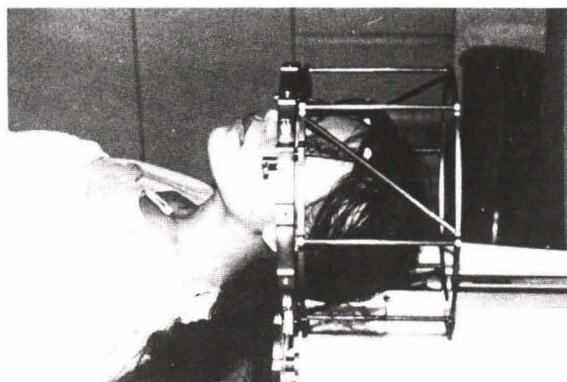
The patient with BRW headring and localizing frame during CT scanning.
